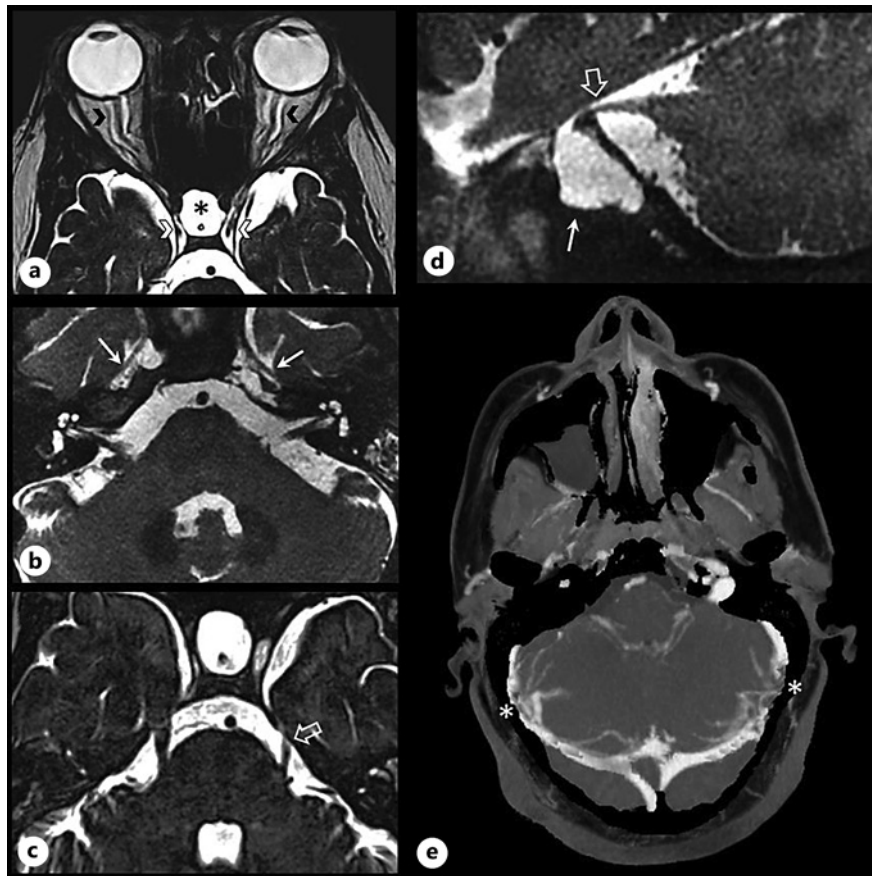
Brain MRI (a–d) and venous angio-CT (e). a Axial HR T2 showing bilateral distension of optic nerve sheaths (black arrowheads), distension of oculomotor nerve sheaths within cavernous sinuses (white arrowheads), and empty sella (black asterisk). b Axial HR T2 showing bilateral cavum trigeminal meningoceles (white arrows). c Axial HR T2 showing atrophy of left trigeminal nerve (empty arrow). d Sagittal HR T2 showing atrophy of left trigeminal nerve (empty arrow) and left cavum trigeminal meningocele (white arrow). e Bilateral venous transverse sinus stenosis before stenting (white asterisk). HR, high resolution.
